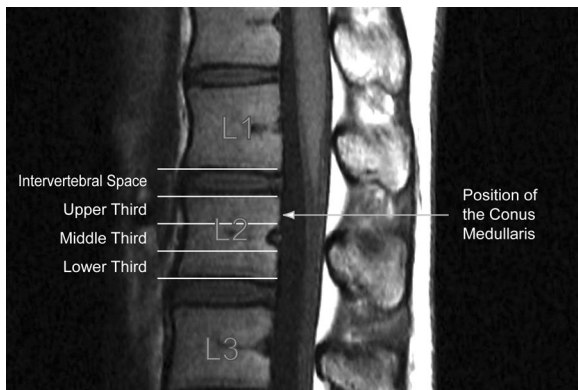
Magnetic resonance image demonstrating the method for determining the conus medullaris position, defined as the most distal point of the cord that can be visualized on the sagittal sequence. Each vertebra and intervertebral space was divided into four segments: upper, middle, and lower thirds of the vertebral body, and intervertebral space. L = lumbar vertebra.
